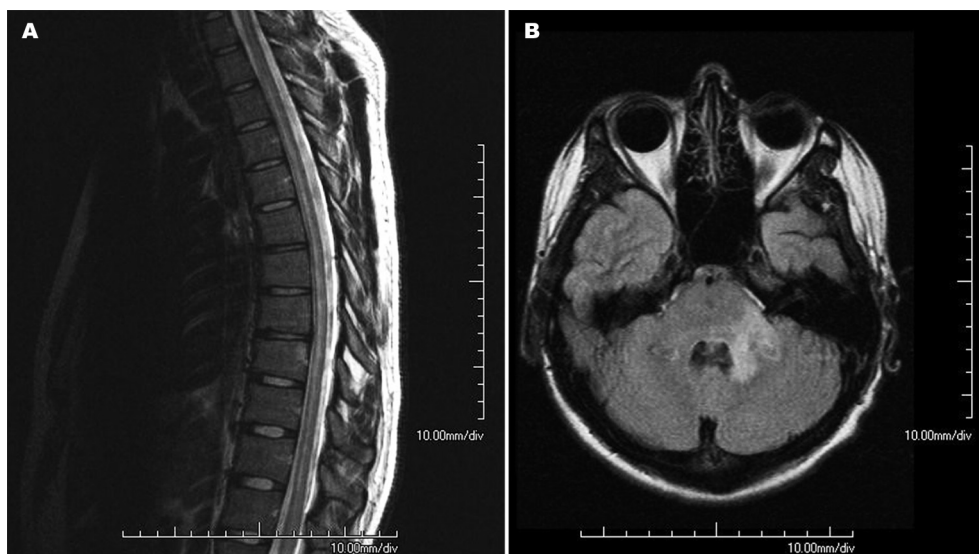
[A] Magnetic resonance imaging (MRI) showing areas of high signal intensity on fluid attenuation inversion recovery (FLAIR) in the left middle cerebellar penduncle, and right dorsal medulla oblongata. [B] Magnetic resonance imaging (MRI) demonstrating an extensive multilevel linear area of high signal intensity on T2 weighted along the cervico-thoracic spinal cord.
